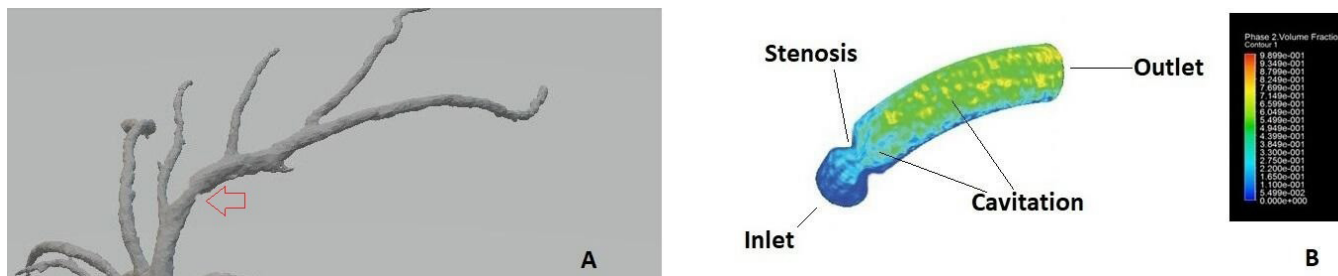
Three-Dimensional reconstruction model of a left coronary artery from a cardiac CT. The stenosis is marked with a red arrow. (B) Demonstration of cavitation in concentric stenosis
